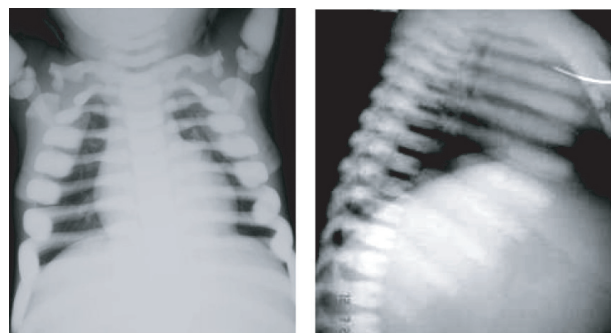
Radiograph of the chest showing generalized sclerosis or increased bone density on thoracic vertebrae, costae, scapula, vertebra, and humerus
